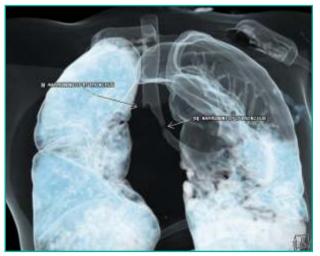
CT 3D reconstructed image -Airbronchgram-Shows Right bronchus completely obstructed and left bronchus partially obstructed.
